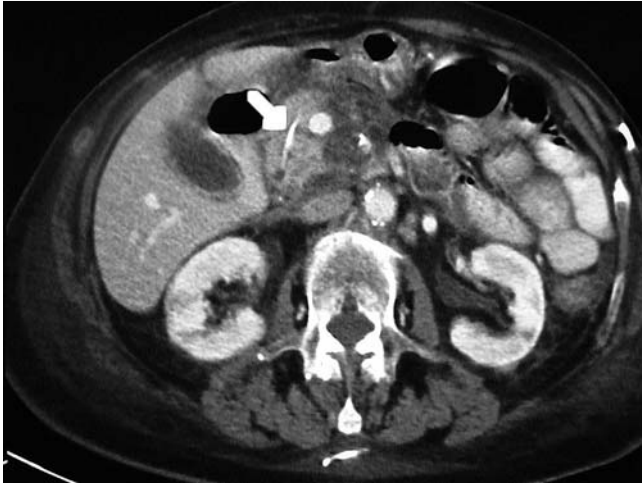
CT scan showing the migrated pancreatic stent in the pancreatic duct (arrow). There are signs of acute postendoscopic retrograde cholangiopancreatography (ERCP) pancreatitis.
